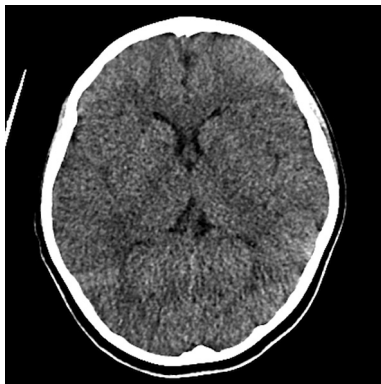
Axial non-contrast computed tomography of the head at presentation.
